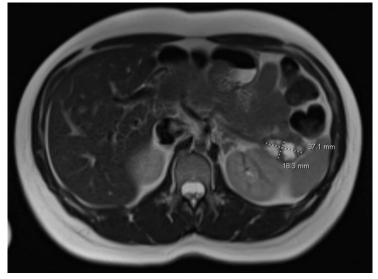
MRI abdomen showing 3.7 cm pancreatic tail mass
